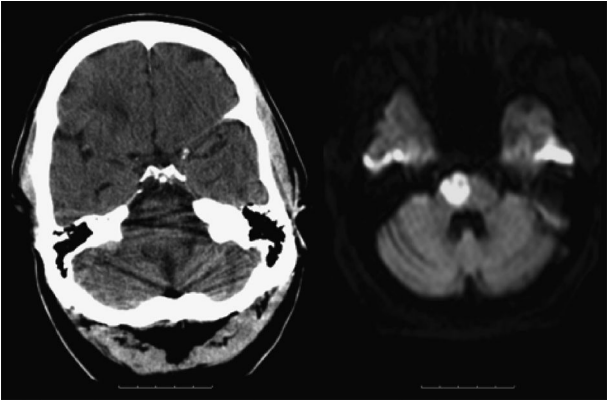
A brainstem infarct on CT and MRI showing the much better sensitivity of MRI to lesions in the posterior fossa. The CT image on the left is very difficult to interpret. On the right is the DWI MR image which clearly shows the abnormal area of infarction. The symmetrical areas of high signal in the temporal lobes on MRI are due to artefact caused by nearby air cells in the bone. © Anthony Pereira.
